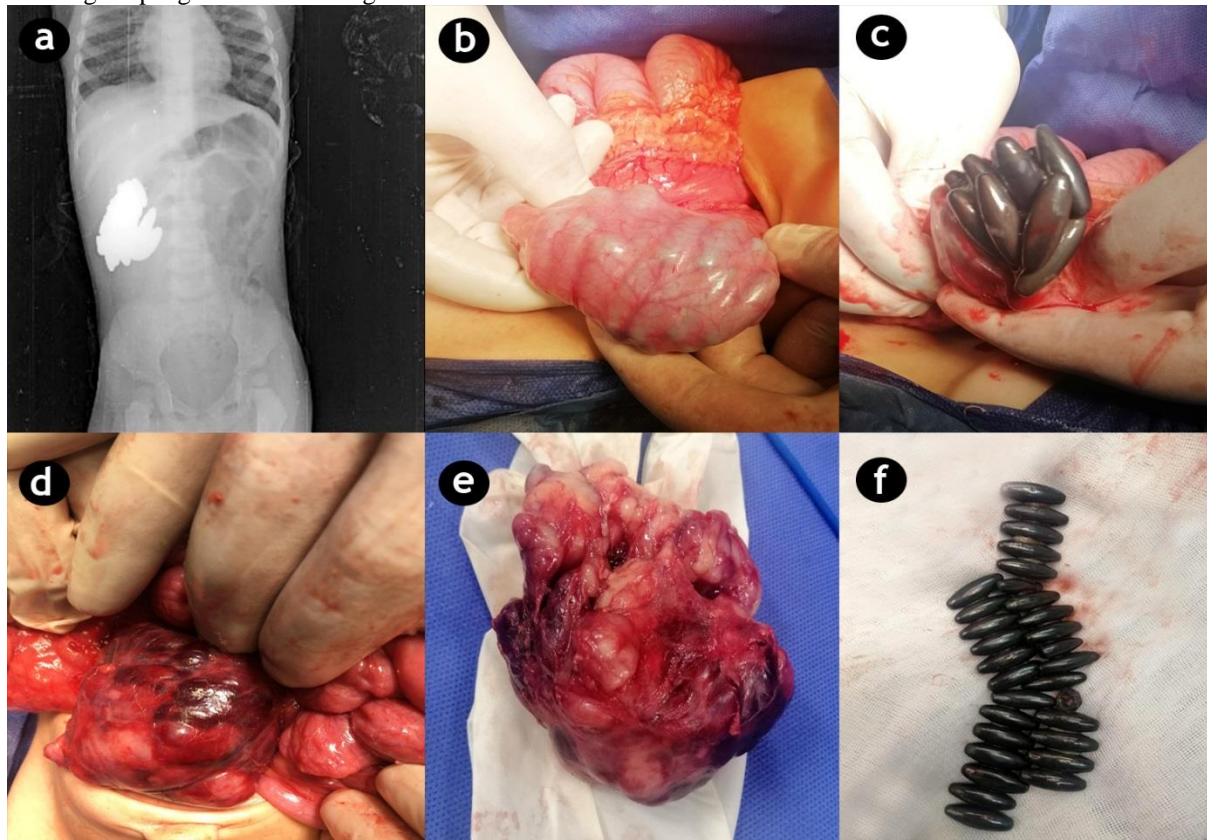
Multiple FB ingestion. (a) Plain x-ray showing aggregated radio-opaque shadows in the right hypochondrium; (b) Multiple FBs inside the stomach; (c) After opening the anterior wall of stomach to extract the FBs; (d) The accidentally discovered mass; (e) After complete excision of the mass; (f) Extracted FBs.
